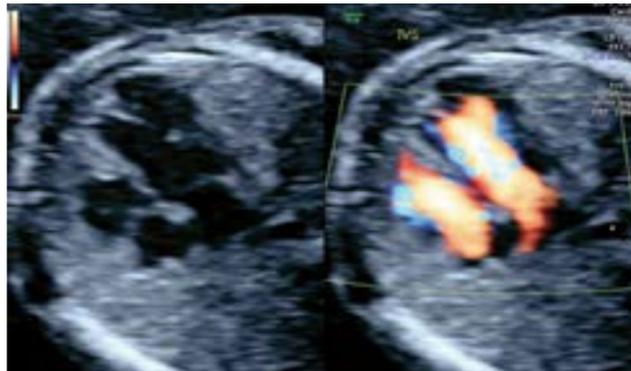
Split screen images of B-mode and colour Doppler of the 4 chamber heart with flow seen from the left ventricle into the defect
